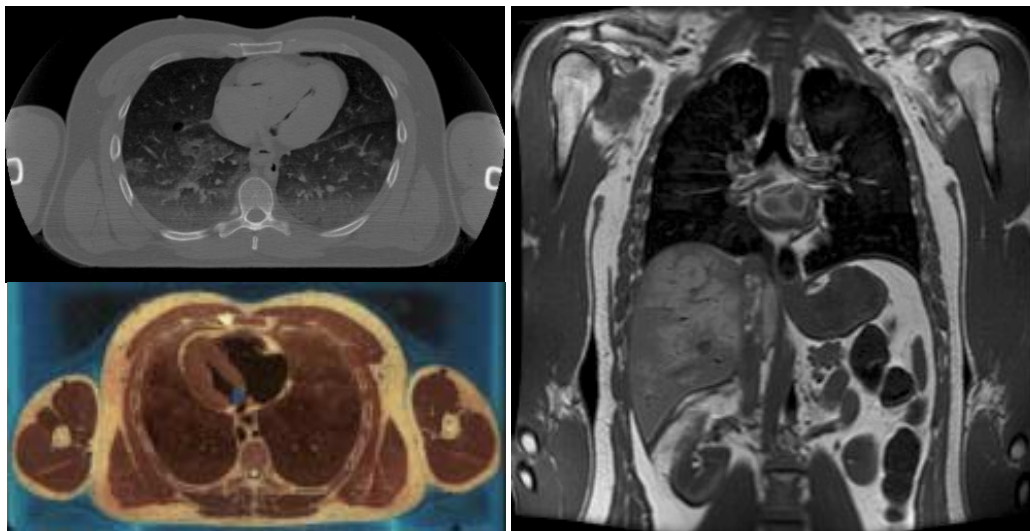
Visible Human male's thorax. CT (top left), MRI (right), Optical Cryosection image (lower left)
